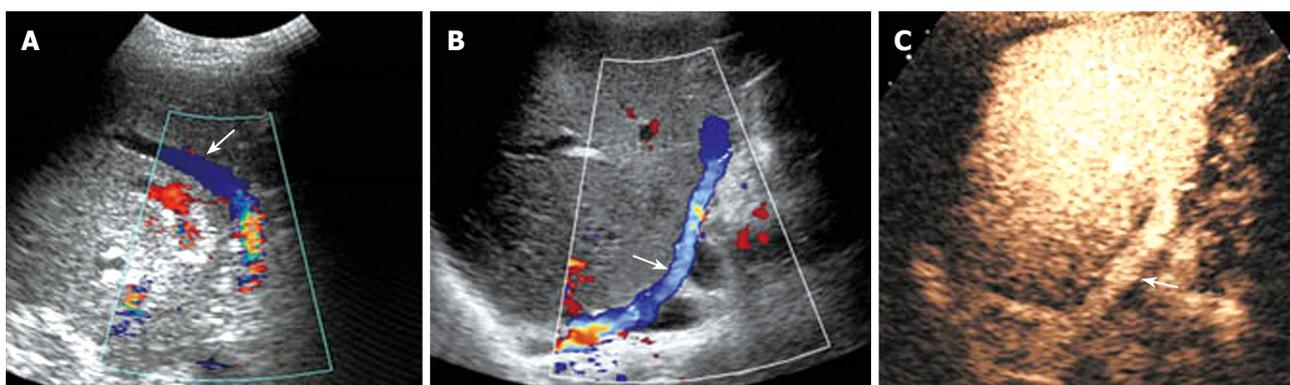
Color Doppler ultrasonography showing large MHV tributaries (arrow) in segment V containing hepatofugal venous flow (A), vessel grafts (arrow) draining the IVC along the surgical margin of liver graft (B), and vessel graft (arrow) filled with contrast agent on contrast enhanced ultrasound indicating the vessel graft patency (C).
